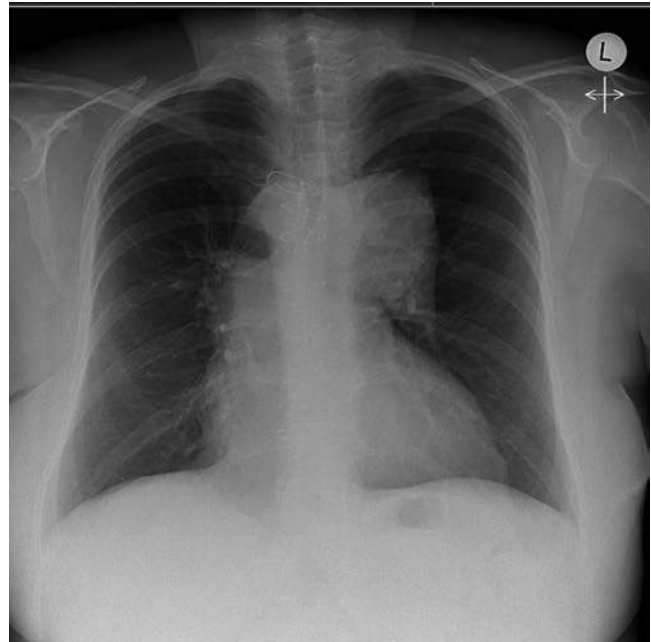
Chest radiograph of adult patient with tetralogy of Fallot with absent pulmonary valve syndrome and pulmonary valve replacement. Note the grossly dilated hilar pulmonary arteries bilaterally and the rather sparse intrapulmonary vessels. (Courtesy Dr. Michael Rubens, Royal Brompton Hospital, London.)
